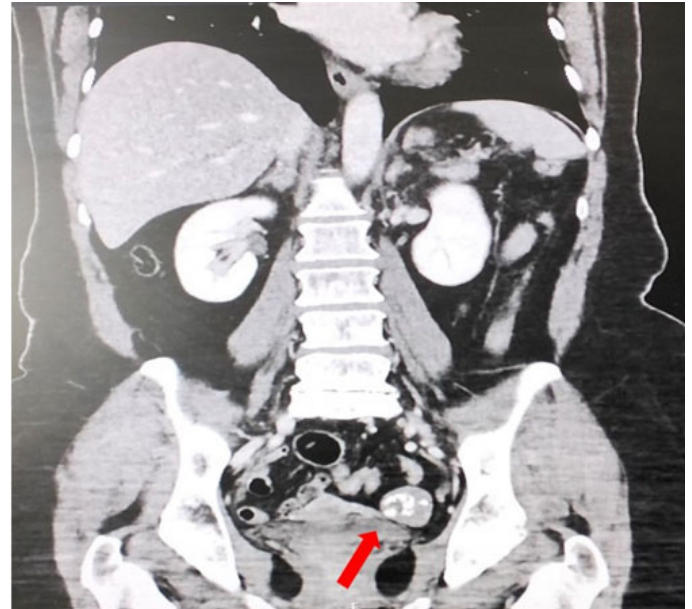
Computed tomography scan showing a solid mass (3.5 cm^3) (red arrow) in the left adnexal region.
